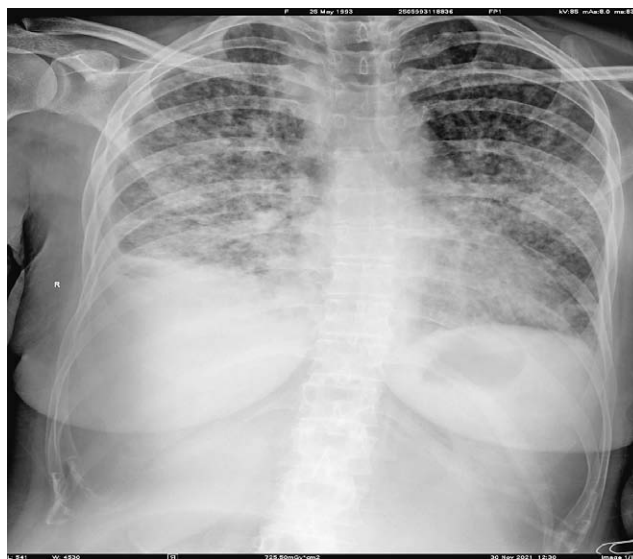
Radiography of the heart and lungs after infliximab therapy (third dose of the drug). Acute respiratory distress syndrome
